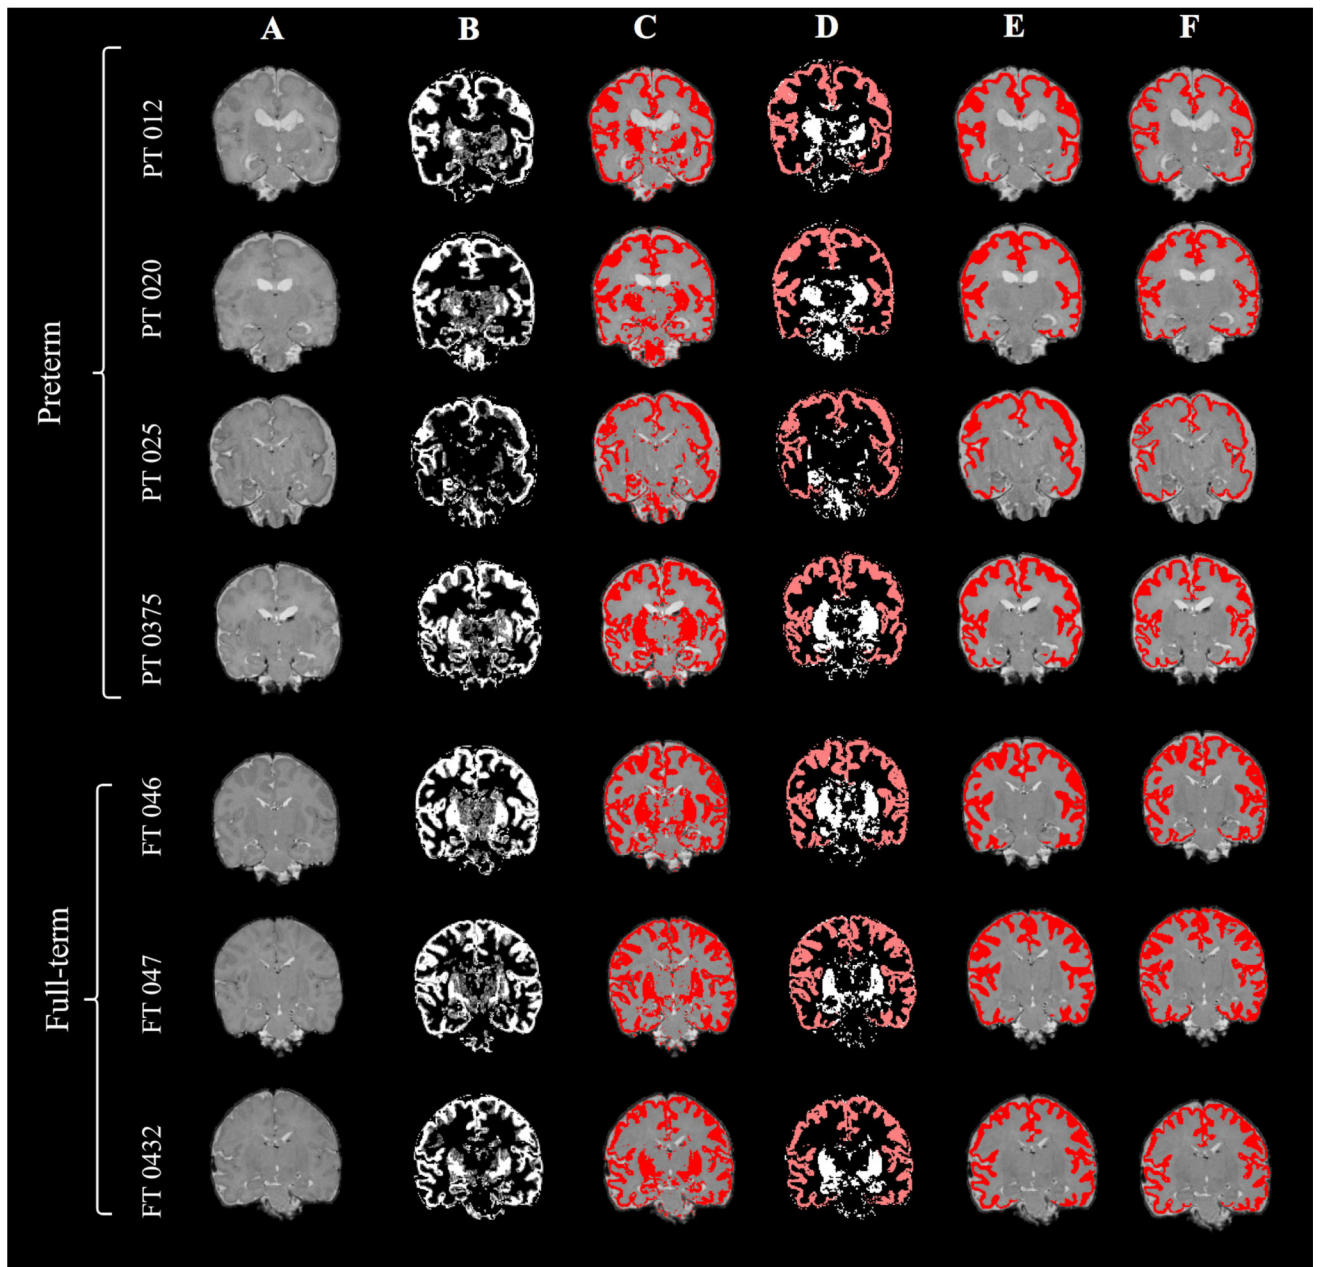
Images for all subjects in the training set. A) Linearly registered T2-weighted MRI images. B) cGM partial volume estimation. C) FAST segmentation. D) FAST segmentation (white) with Bayesian mask (red) E) Final segmentation using Bayesian technique and k-NN smoothing F) Manual segmentation.
